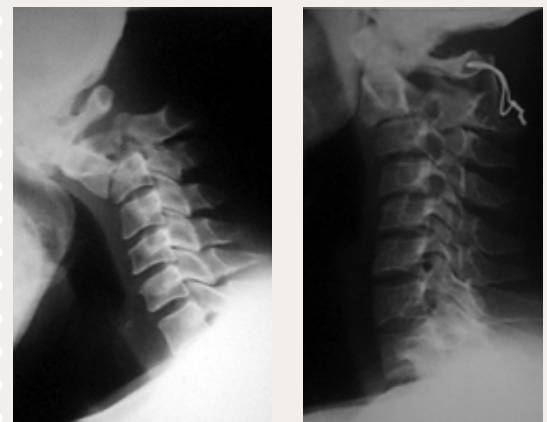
Radiograph showing a) fracture of the pedicle of C2 sustained during a road traffic accident leading to C2/3 subluxation and b) after being treated by wiring and bone graft
